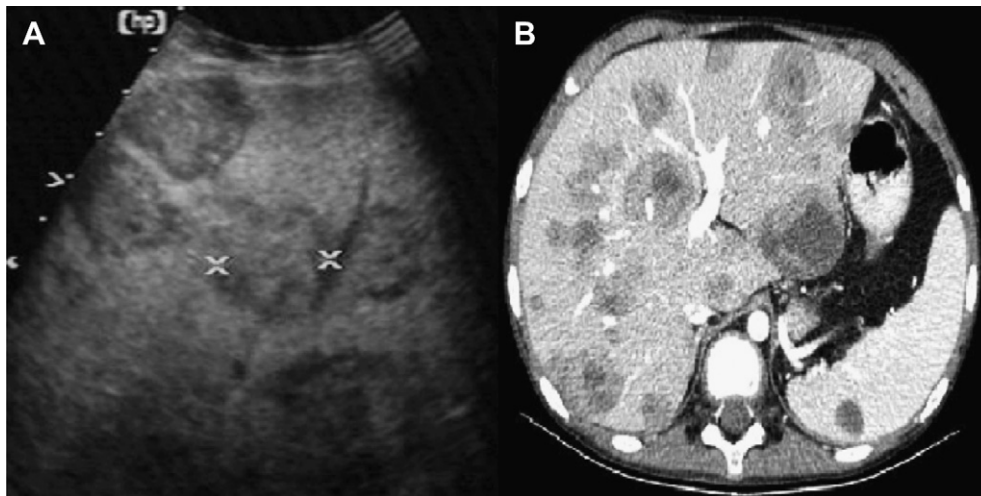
(A) Hepatic lymphoma, case 6: Multiple heterogeneous lesions with peripheral halo and hepatomegaly. (B) CT: Multiple hypodense lesions and rim enhancement.
